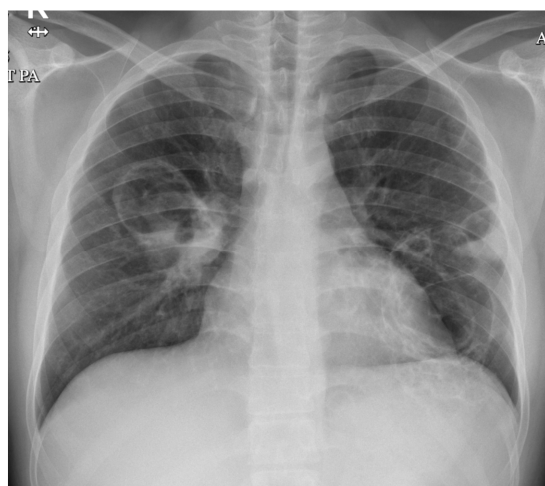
Follow-up chest radiography after one week of therapy revealed multiple cavitory lesions in both lung fields that remained relatively unchanged compared with the previous examination.
